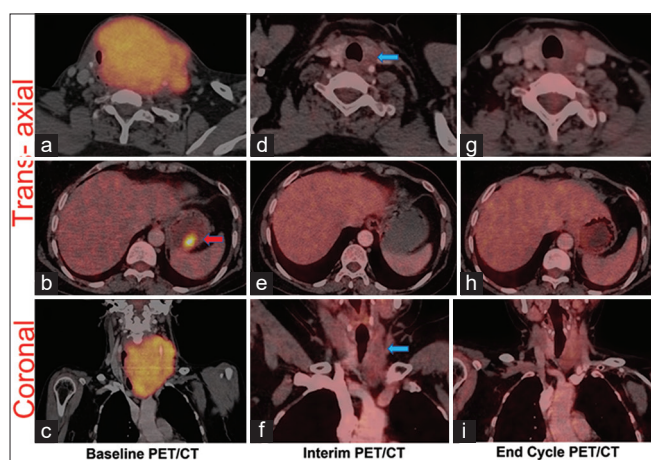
Baseline images (a and c) revealed increased uptake in the neck region (predominantly left), and increased tracer uptake in the stomach suggestive of gastric involvement (b, red arrow). Interim images (d and f) after chemotherapy revealed a hypodense lesion in left thyroid lobe region with faint FDG uptake (blue arrow) and disappearance of fundus uptake (e). End cycle images revealed complete disappearance of thyroid mass lesion (g and i) with absent uptake in the stomach (h) suggestive of CMR
